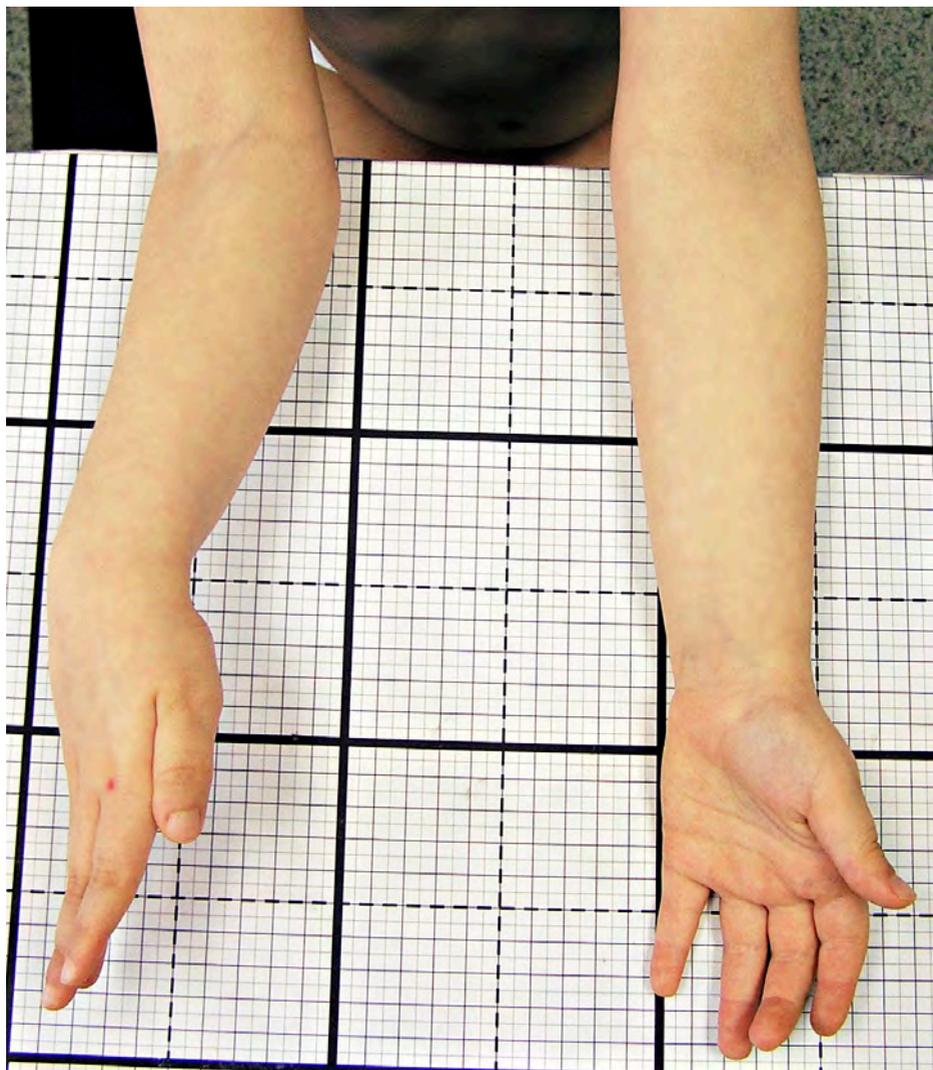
A–D. Typical clinical finding (A) and X-ray (B) of isolated congenital proximal R-U synostosis with fixed pronation of forearm. C. Derotative osteotomy at the region of R-U synostosis, correction in the neutral position (or in 10–20 degrees of pronation), fixation by external fixator Wagner. D. Complete consolidation of osteotomy after 3 months.
